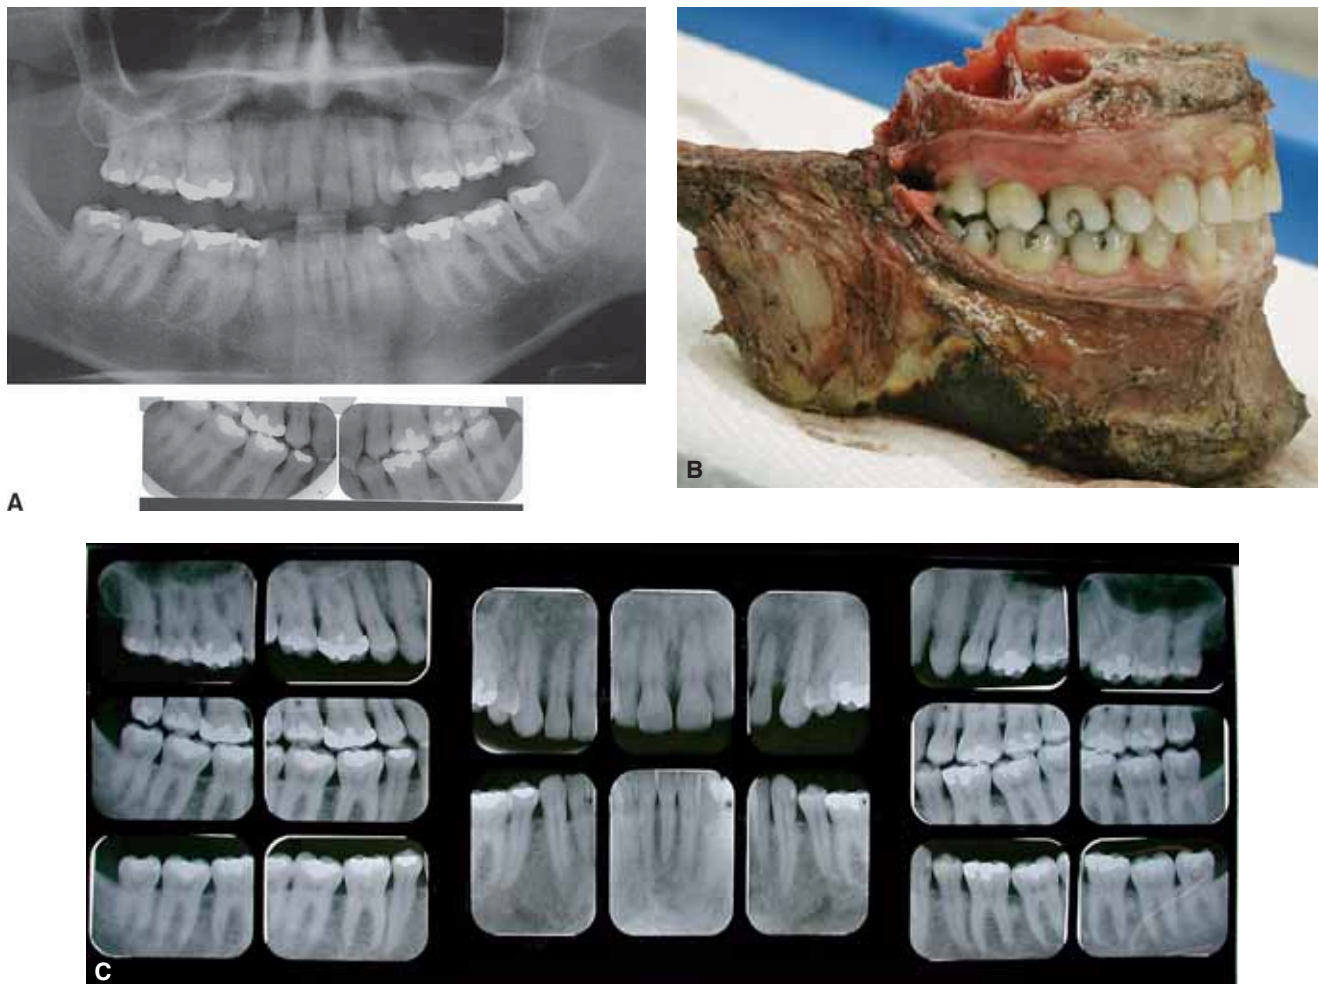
A. Antemortem films from the victim of an aircraft crash and severe burning. Original films must always be provided to the forensic dentist so that appropriate anatomic orientation can be made. Bitewings are the most helpful images for use in comparison of restoration morphology and pulpal conditions such as recession, pulp stones, etc. The antemortem charting of this individual's dentition can be seen in Figure 12-5A. B. For this victim, the jaws had to be resected to permit appropriate detailed clinical and radiographic examination. When properly dissected and cleaned, all tooth surfaces can be directly visualized, examined, photographed, and radiographed. (The forensic dentist must have appropriate permission from the medical examiner or coroner to remove body parts such as the jaws. Only when the victim is not viewable in a funeral home open casket setting, can this procedure be permitted.) C. The postmortem dental radiographs are shown here and can be easily compared to the antemortem records found in A. Close attention must be paid to tooth and root morphology, sinuses, trabecular patterns, bone levels, and restorations.
